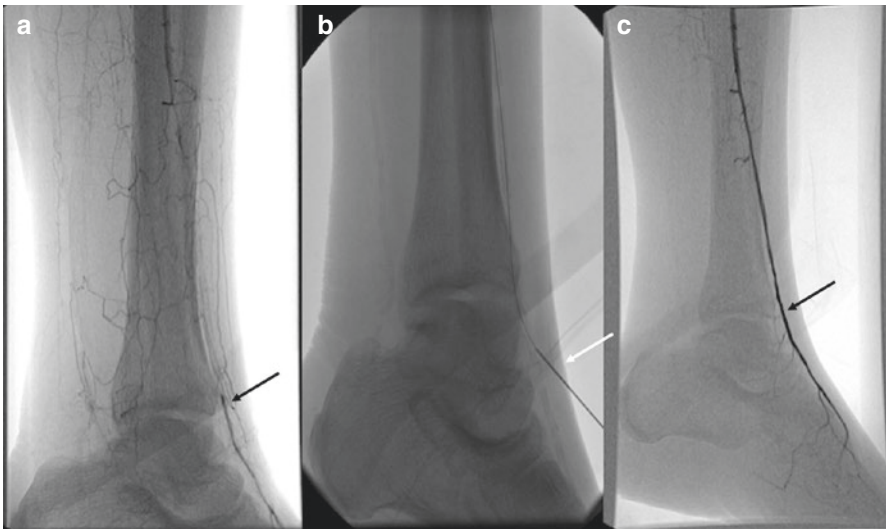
Retrograde pedal access. (a) Pre-treatment angiogram demonstrates an occluded distal anterior tibial artery with a patent dorsalis pedis artery (black arrow) which could not be reached via an antegrade approach. (b) A direct puncture of the patent distal anterior tibial artery was performed under ultrasound guidance and a guide wire was passed through the occlusion in a retrograde fashion successfully (white arrow). (c) Completion angiogram demonstrates restored patency of the distal anterior tibial artery (black arrow) following balloon angioplasty over the guide wire from the ipsilateral femoral approach
